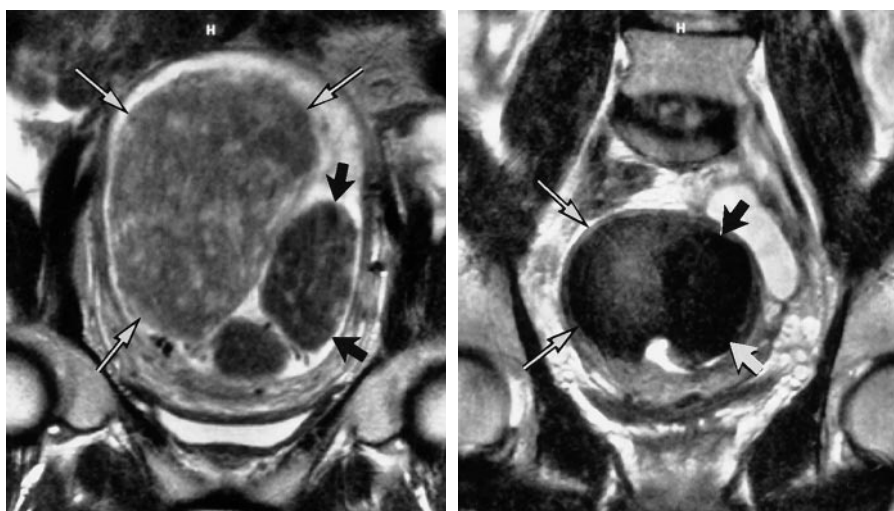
Coronal T2-weighted turbo spin-echo MR images (4,000/99 [effective], 256 × 242 matrix, 220 × 220-mm field of view, 5-mm-thick sections) obtained (a) before and (b) after embolization show that a large high-signal-intensity fibroleiomyoma (long arrows) undergoes a greater reduction in volume after embolization than does a low-signal-intensity fibroleiomyoma (short arrows).
